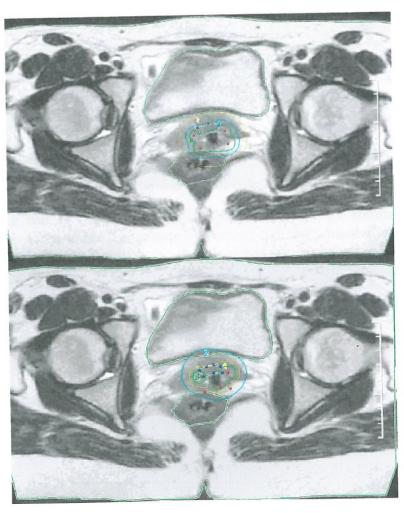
Modifying dose distribution on an axial MR image. The 2,4 and 8 Gy isodose curves (light blue, yellow and green respectively) are presented as well as the OARs (rectum and bladder), the CTV (line connecting blue dots) and the applicators of the device (red dots). While the automatic optimization led to considerable spread of the 8 Gy dose into the rectum a manual changes of dwell positions and weight ensured a sufficient coverage of the CTV without exceeding dose constrains for the OARs.
